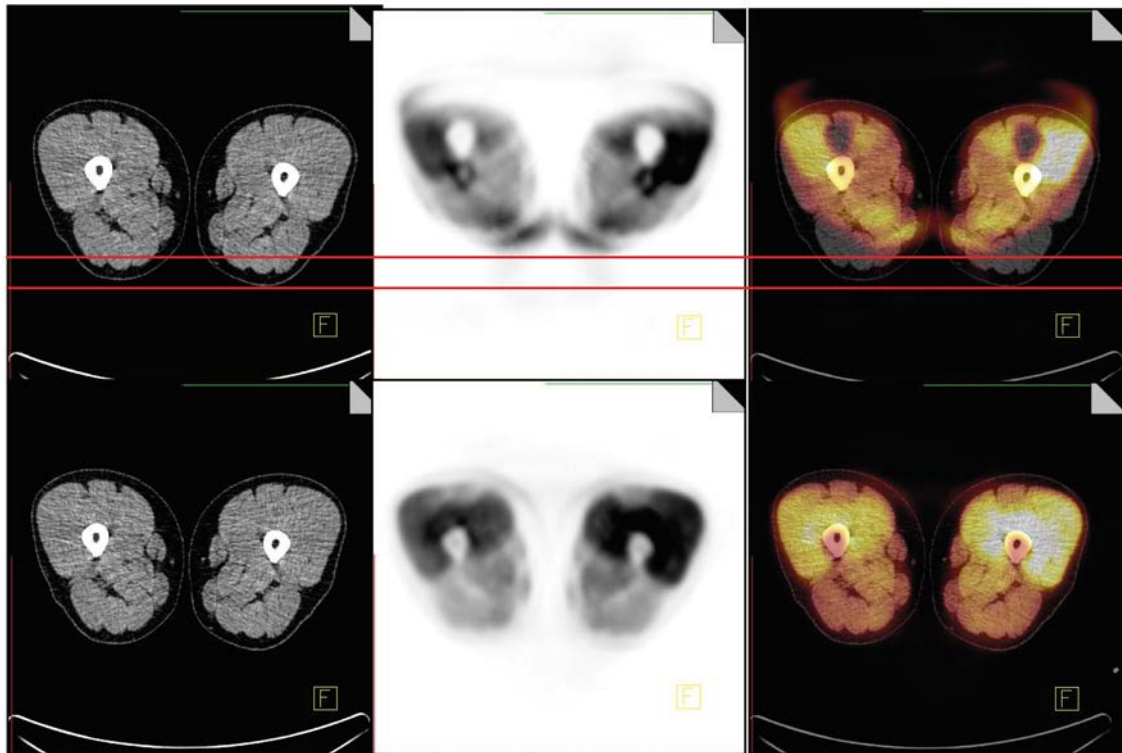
Transaxial images of CT, AC-PET and fused AC-PET/CT demonstrating effects of PET-CT misalignment (upper panel) following incorrect retrospective data correction. After rectifying the data entry for table height and activity, the post-processed images were free of artefacts (lower panel).
